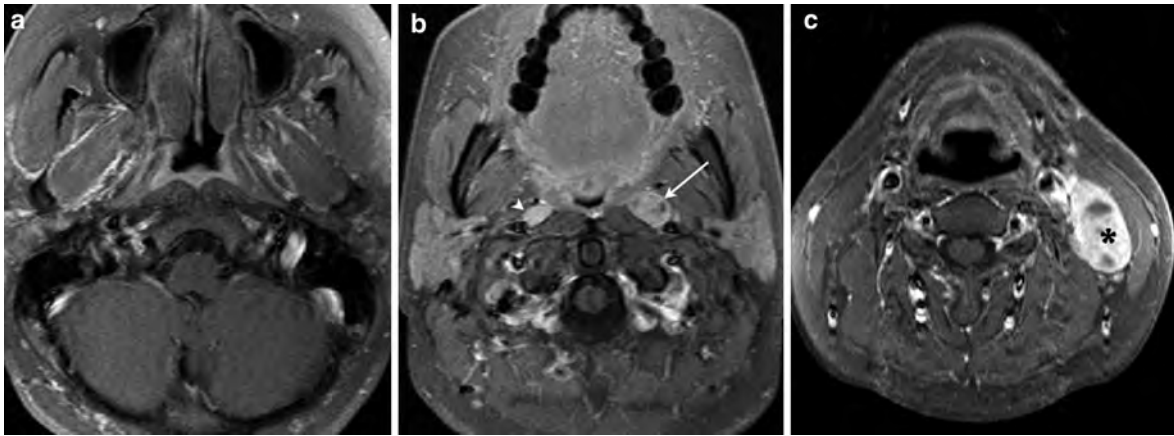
Occult nasopharyngeal carcinoma in a 61-year-old male who presented with left cervical lymphadenopathy. a Axial contrast-enhanced fat-saturated T1-weighted MR image through the nasopharynx shows no evidence of any tumour, particularly in the lateral pharyngeal recesses. b Axial contrast-enhanced fat-saturated T1-weighted MR image at the level of the oropharynx shows an enlarged left lateral retropharyngeal
